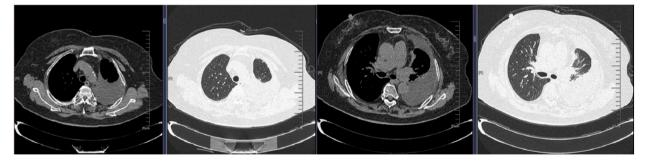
CT images taken on 15 April 2021 revealed a massive amount of left pleural effusion and collapse consolidation of the adjacent left lung tissue.
